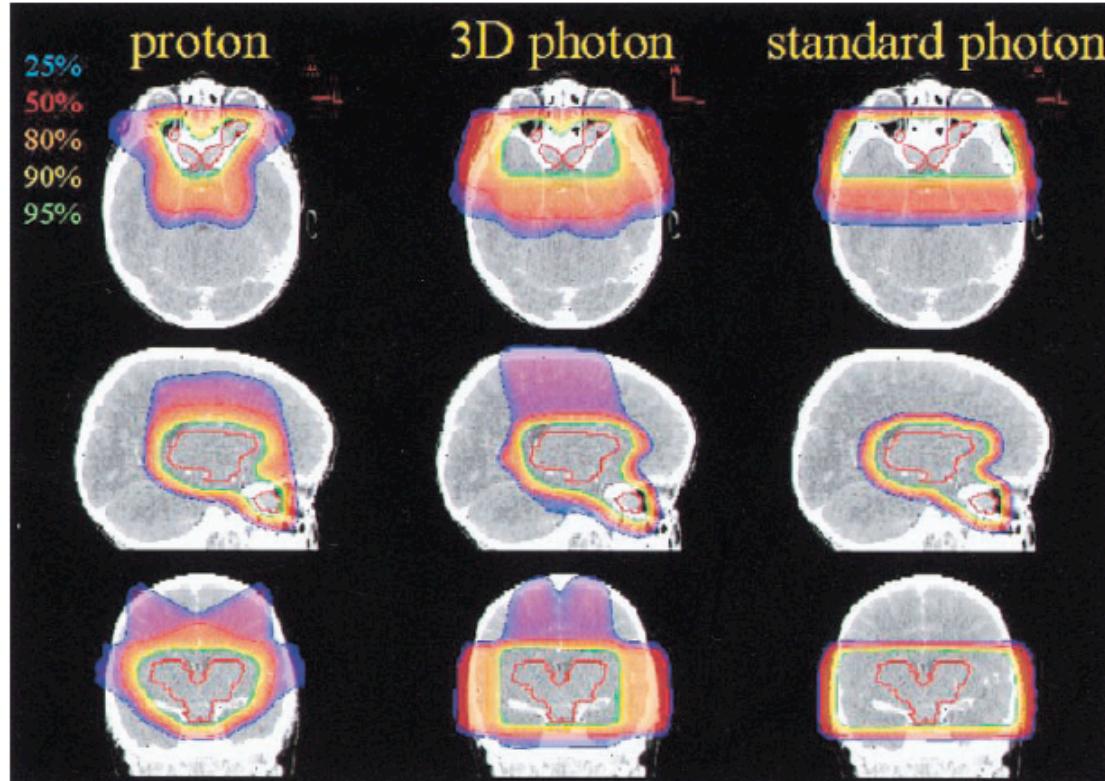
Dose distribution of proton, 3D photon, and standard photon plans superimposed onto representative slices of the planning CT in axial, sagittal, and coronal planes. Display of GTV in red, and 25% (blue), 50% (red), 80% (orange), 90% (yellow), and 95% (green) isodose lines in color-wash technique. Prescribed total dose was 54 CGE/Gy. CT scan of a 5-year-old male patient (patient 5, Table 1) with extensive bilateral optic pathway glioma and associated diagnosis of neurofibromatosis type 1 (NF1).
